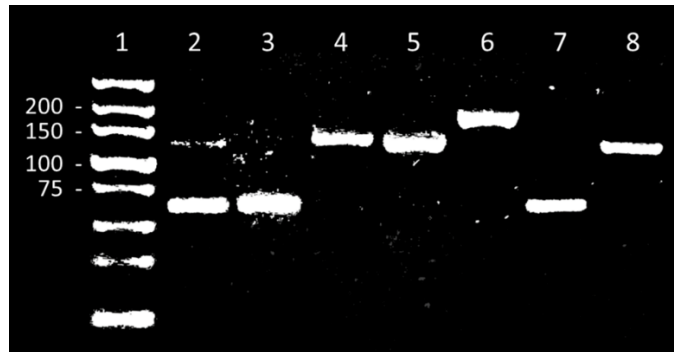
5% agarose gel dyed with EtBr. From left, well 1: Ladder 300-10 bp; well 2: *ISYNA1* CT; well 3: *IMPA2* CT; well 4: gDNA from bipolar 2 no RT; well 5: gDNA from bipolar 2 RT; well 6: ACTG1 of bipolar 1 RT; well 7: *IMPA2* of BD2 RT well 8: *ISYNA1* of BD2 RT.
